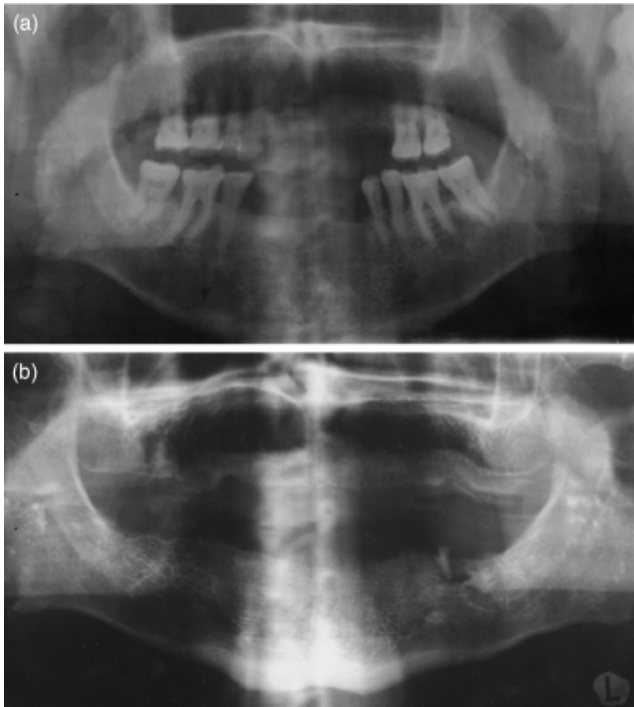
Example of dental panoramic tomography radiographs within a patient record. (a) Radiograph taken in 1990 to assess periodontal bone loss. (b) Same patient radiographed in 1993 following loss of all but a small root fragment on the patient's left side.
